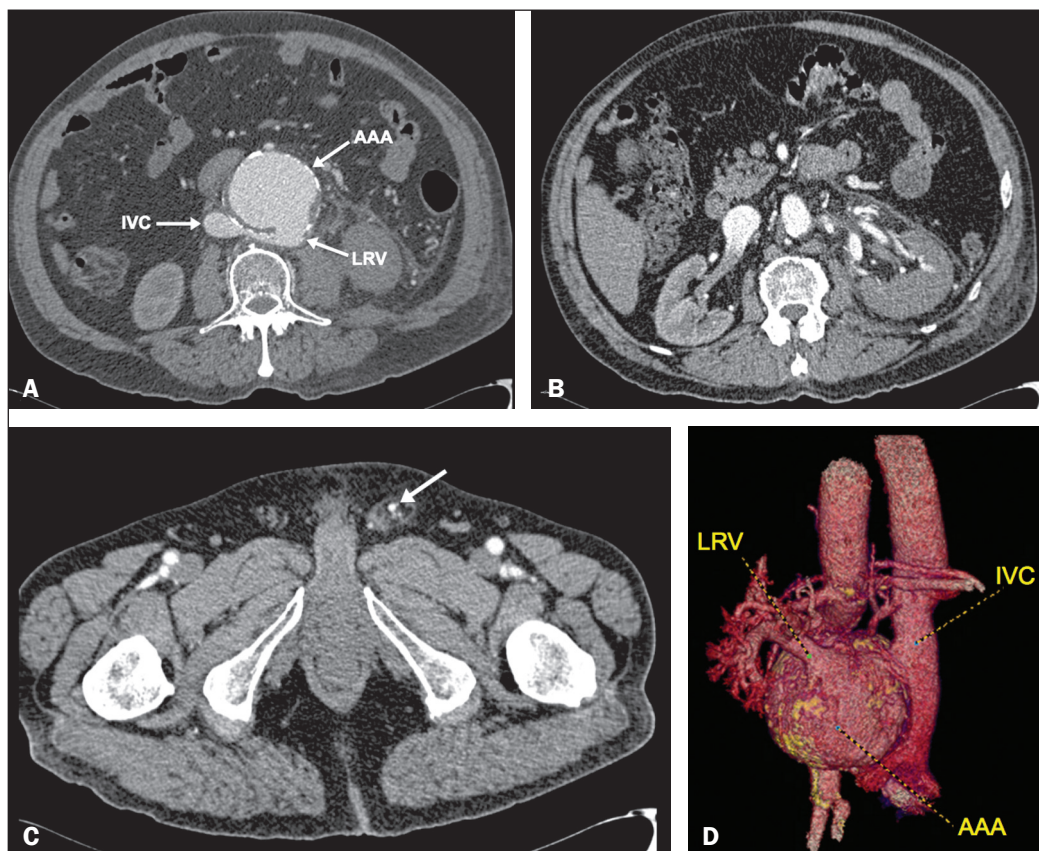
A-C: Contrast-enhanced axial CT slices showing equal opacification of the infrarenal aorta, a retroaortic left renal vein (LRV), and the inferior vena cava (IVC), confirming the fistula between an abdominal aortic aneurysm (AAA) and the aberrant left renal vein (A). Note the reduced contrast enhancement of the left kidney (B) with dilatation and arterial enhancement of the left gonadic vein (arrow, C), accompanied by left varicocele. D: Contrast-enhanced CT, with three-dimensional reconstruction, in a posterior view, showing the retroaortic left renal vein in communication with the abdominal aortic aneurysm.
